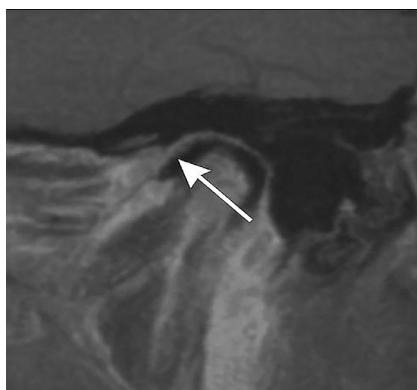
MRI image of the TMJ before osteopathic treatment (Patient A)
